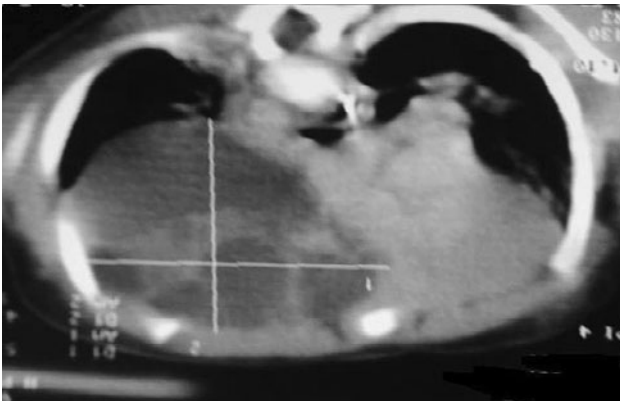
Preoperative chest computed tomography (CT) (prone position) shows large multiseptate cystic mass with solid component in anterior mediastinum ($5.3 \times 4.6 \times 5.6$) on *left side* extending to superior mediastinum, pushing great vessels posteriorly and heart towards *right side*, with partial effacement of left mainstem bronchus and collapse of left lower lobe
